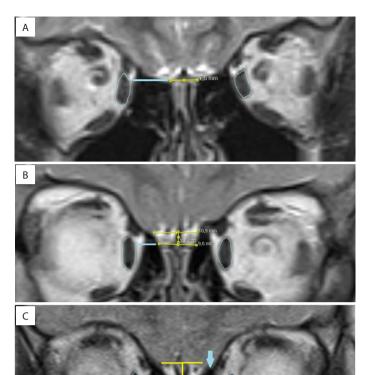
Coronal T2-weighted MR images show that: Type I Ethmoid roof (a): the line drawn from the upper contour of the ethmoid roof (yellow line) does not exceed the upper 1/3 section of the medial rectus muscle blue circles). Type II Ethmoid roof (b): the line drawn from the upper contour of the ethmoid roof (yellow line at the bottom) is at the border of the upper 1/3 of the medial rectus muscle (blue circles). The upper yellow line runs perpendicular to the upper contour of the cribriform plate. Type III Ethmoid roof (c): the line drawn from the ethmoid roof (blue line, open arrow) passes through 1/2 of the medial rectus muscle (blue circles). The closed arrow on
